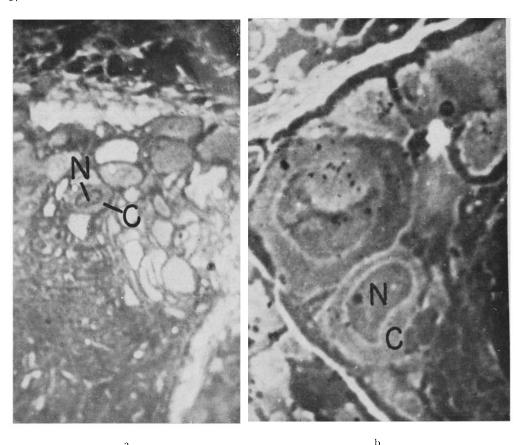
Nerve cells from Ganglion olfactorium in *Helix pomatia*. N, nuclei; C, cytoplasm. Thickness of section: $_5\mu$. Magnification: a) $\sim _{75}\times$, b) $_{285}\times$. 3000 volts x-rays, filtered through 9 μ Al. The white areas are opaque to x-rays.
